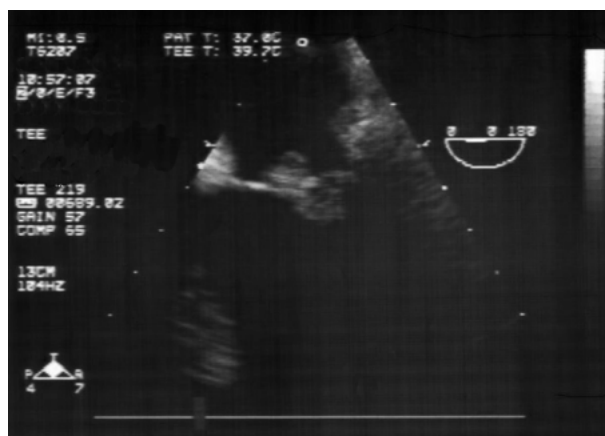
Transesophageal echocardiogram showing a mobile echodensity attached to the atrial side of the anterior leaflet measuring 1.14×0.6 cm.
